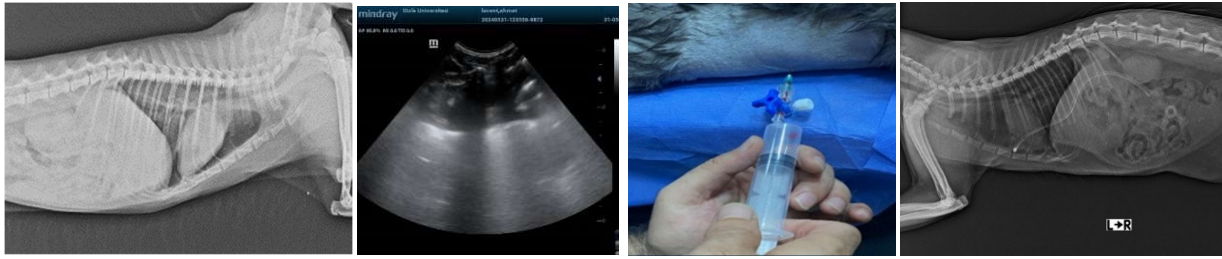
Pneumothorax case; A: thorax radiograph, B: screenshot during TFAST, C: air aspiration by thoracocentesis, D: in another case, a chest tube was placed.
